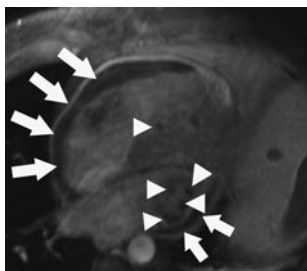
Contrast-enhanced fat-suppressed T1-weighted turbo fast low-angle shot (FLASH) image in the horizontal long axis of the heart shows fibrous pericarditis (arrows) and intramyocardial abscesses (arrowheads).
